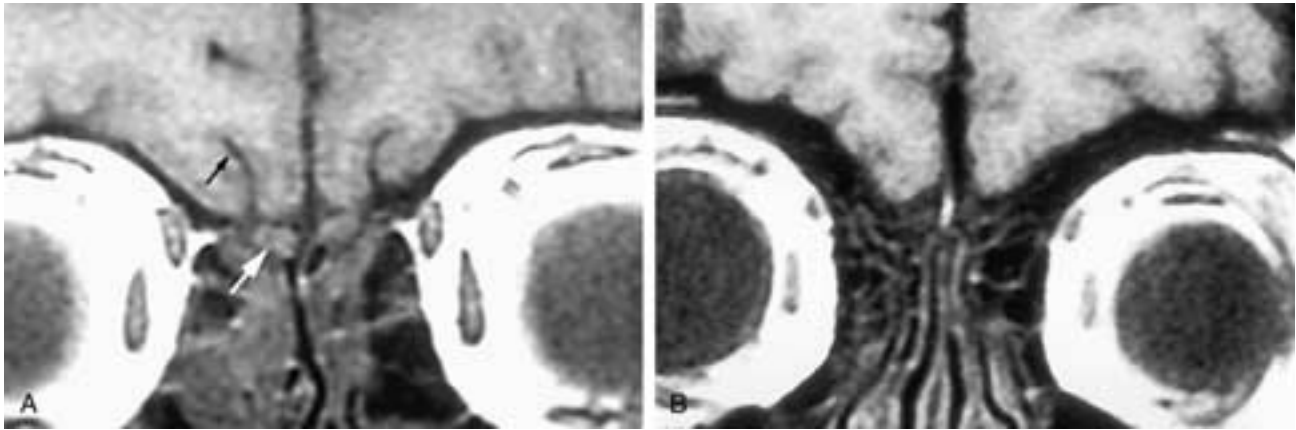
Coronal T1-weighted MR images. In A, a normal patient, the olfactory bulb (white arrow) and olfactory sulcus (black arrow) are well seen bilaterally. In B, a patient with anosmia, olfactory bulbs and sulci are absent in this patient with Kallman's syndrome. (Case courtesy of David Yousem, M.D.)
